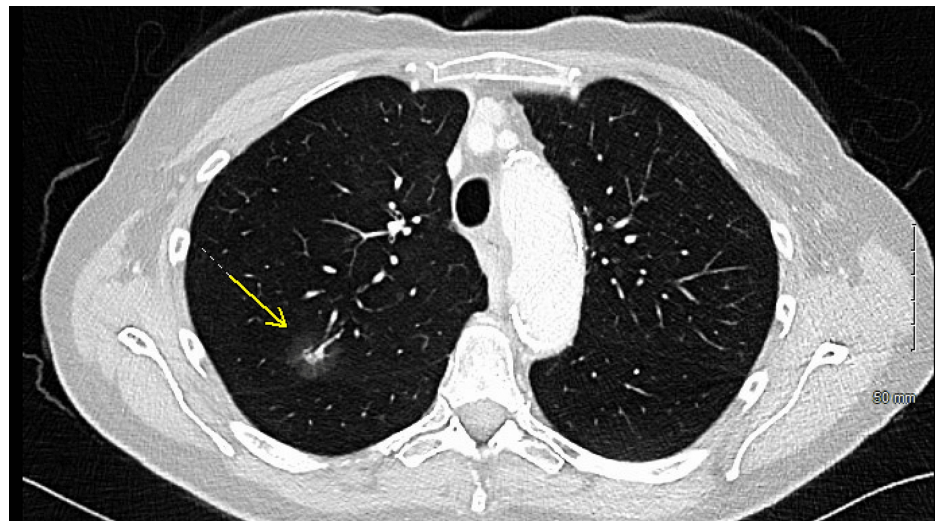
Selected axial contrast-enhanced CT image of the chest demonstrating a part-solid right upper lobe pulmonary nodule (yellow arrow) with a 7 mm solid component and a 20 mm ground-glass component, subsequently confirmed as stage IA1 lung adenocarcinoma.
